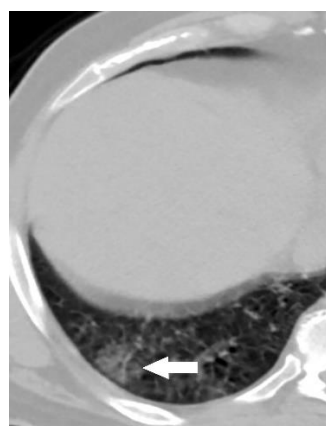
Axial CT image lung window showing a 22 mm ground-glass nodule (arrow) at baseline CT. This nodule would have been classified as a Lung-RADS 3 category in Lung-RADS 1.0, while in Lung-RADS 1.1 and 2.0 it would be classified as a Lung-RADS 2 category
